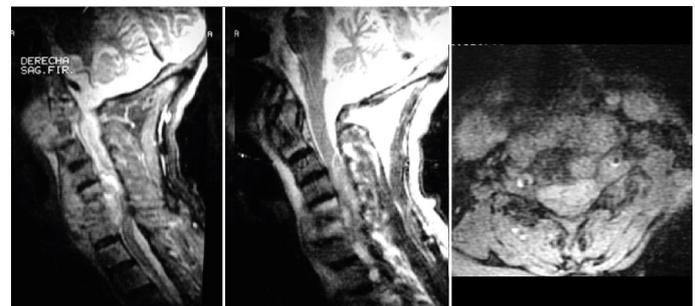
Case 17. MRI sagittal sections T2 without and with contrast and Axial T2 with contrast. Defined as C5-C7, A, C2, O2, + (Region C5-C7, Anterior Location, the PSEA compresses the canal content, Association with disc and bone involvement, Perivertebral positive - anterior).
